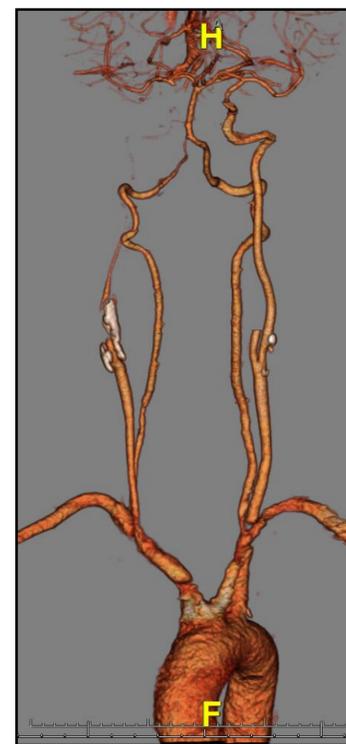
CT angiography at initial presentation
